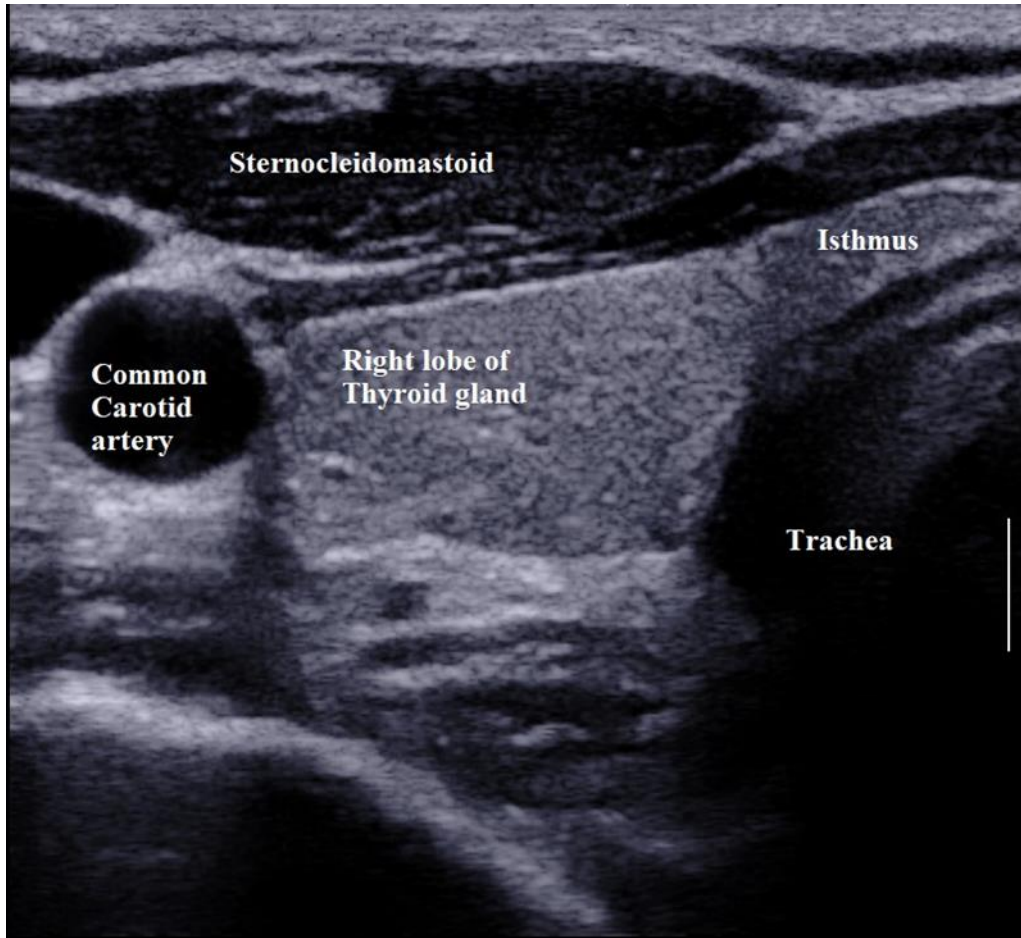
Grey-scale ultrasound features of normal thyroid gland and its anatomical relationship.
